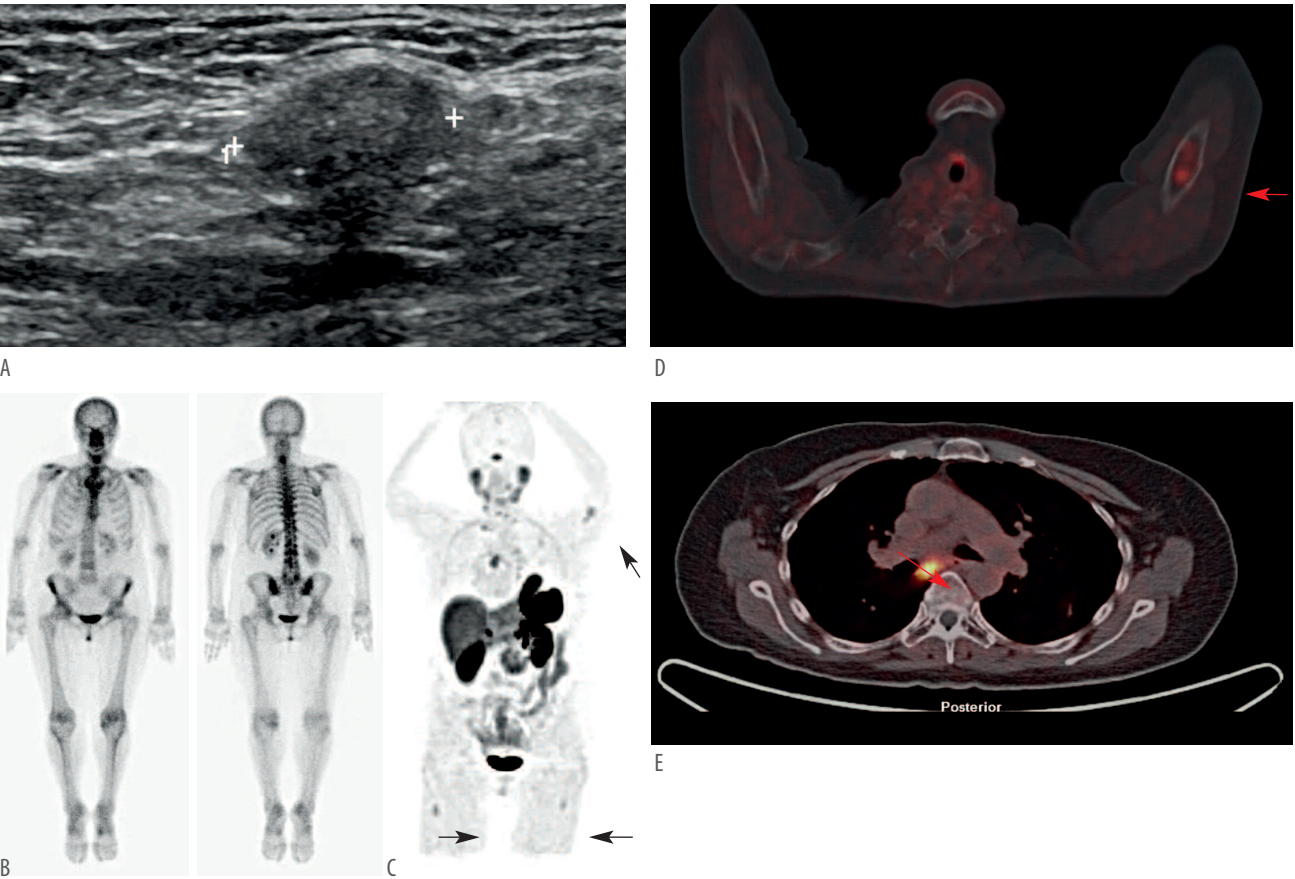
Recurrent MTC. A neck ultrasound demonstrated right cervical lymphadenopathy. (A). Very high calcitonin suggested bone metastases but ^{99m}Tc-HDP bone scan was negative (B). ⁶⁸Ga-Dotatate PET/CT maximum intensity projection (MIP) (C) showing several bone metastases (black arrows). Fused transverse views showing lesions in the left humerus (D) and mediastinum (E) (red arrows).
